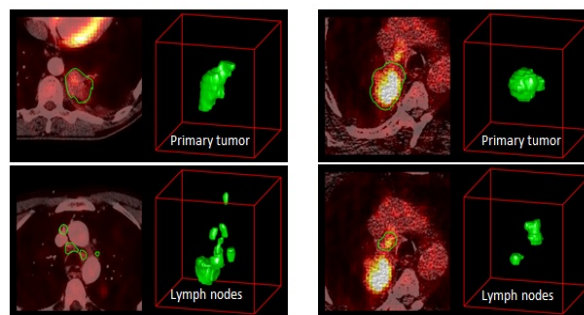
Figure – Fused pre-radiotherapy PET-CT scans of two NSCLC patients with delineated primary tumor and corresponding lymph nodes.
